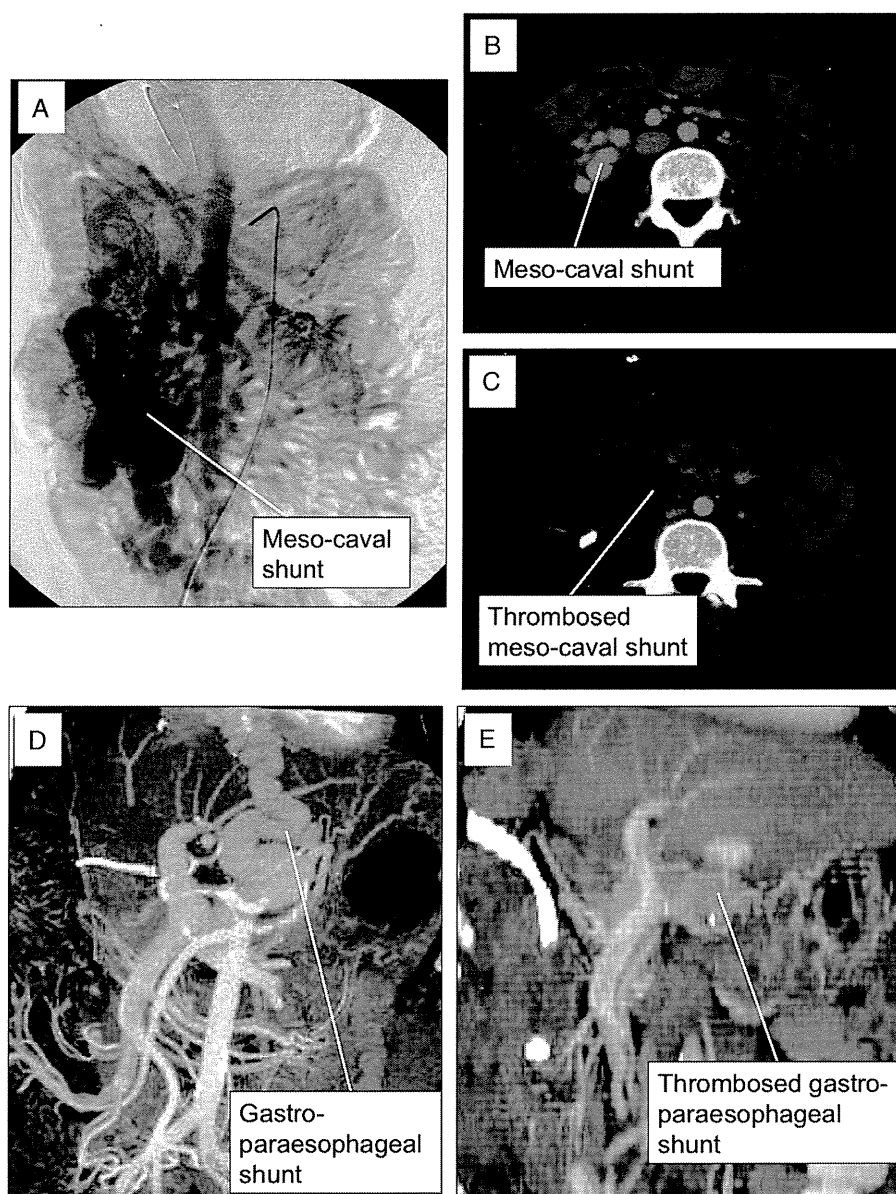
The cases of patient major shunt vessels requiring secondary intervention: Case 4 (A–C) and Case 8 (C, D). Mesenteric arteriogram (A) and computed tomographic scan (B) showed portal steal caused by patent major mesocaval shunt, followed by surgical ligation (C). Multidetector computed tomographic image of patent gastroesophageal shunt after LDLT (D), followed by surgical ligation (E).
